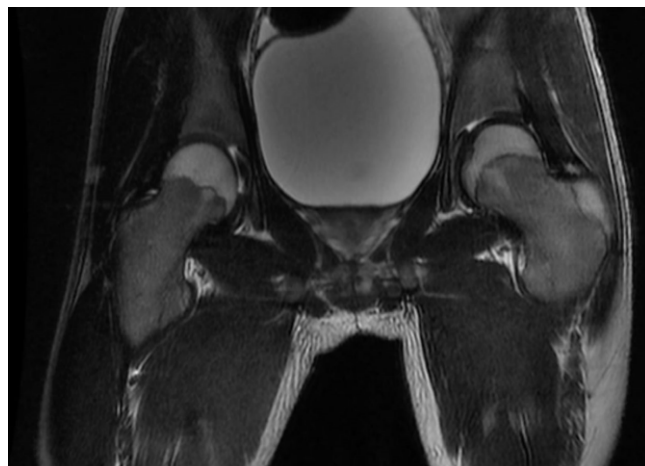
Magnetic resonance imaging at final follow-up (Coronal).
